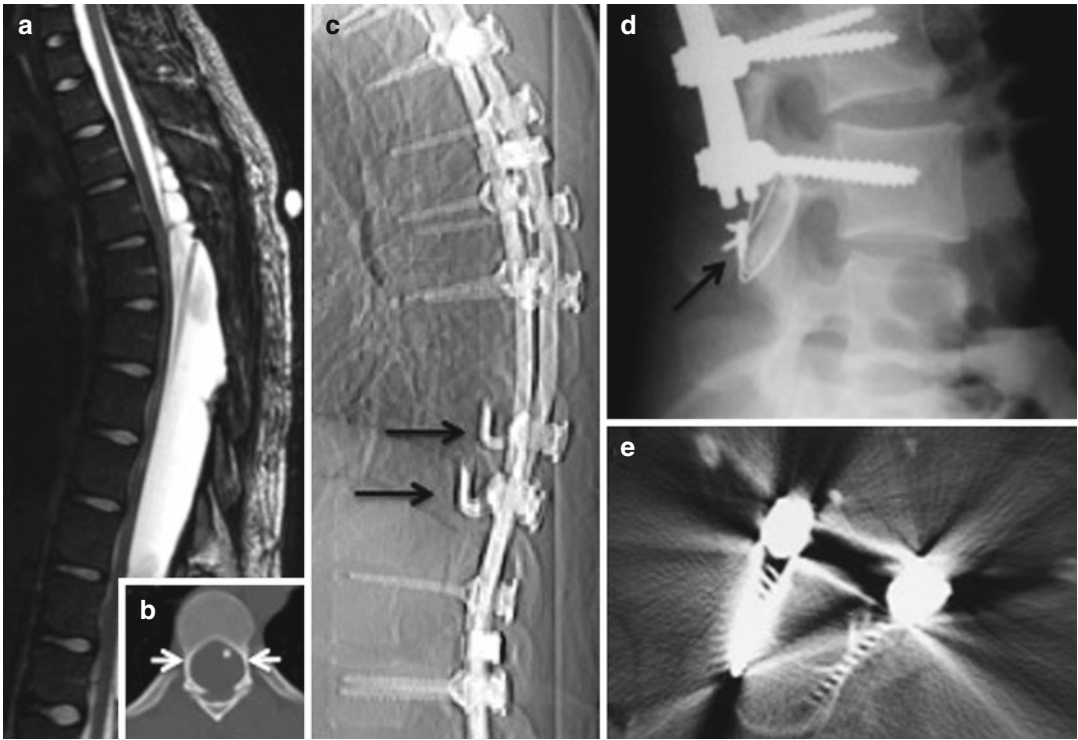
Techniques for fixation in patients with thin pedicles. (a) Preoperative MR image showing large extradural thoracic CSF collection. (b) Postoperative axial CT image showing thinned out pedicles (*arrows*) and cystopleural shunt tubing (hyperdensity in the canal). (c) Postoperative lateral radiograph showing the use of pedicle hooks (*arrows*). (d) Postoperative lateral radiograph
